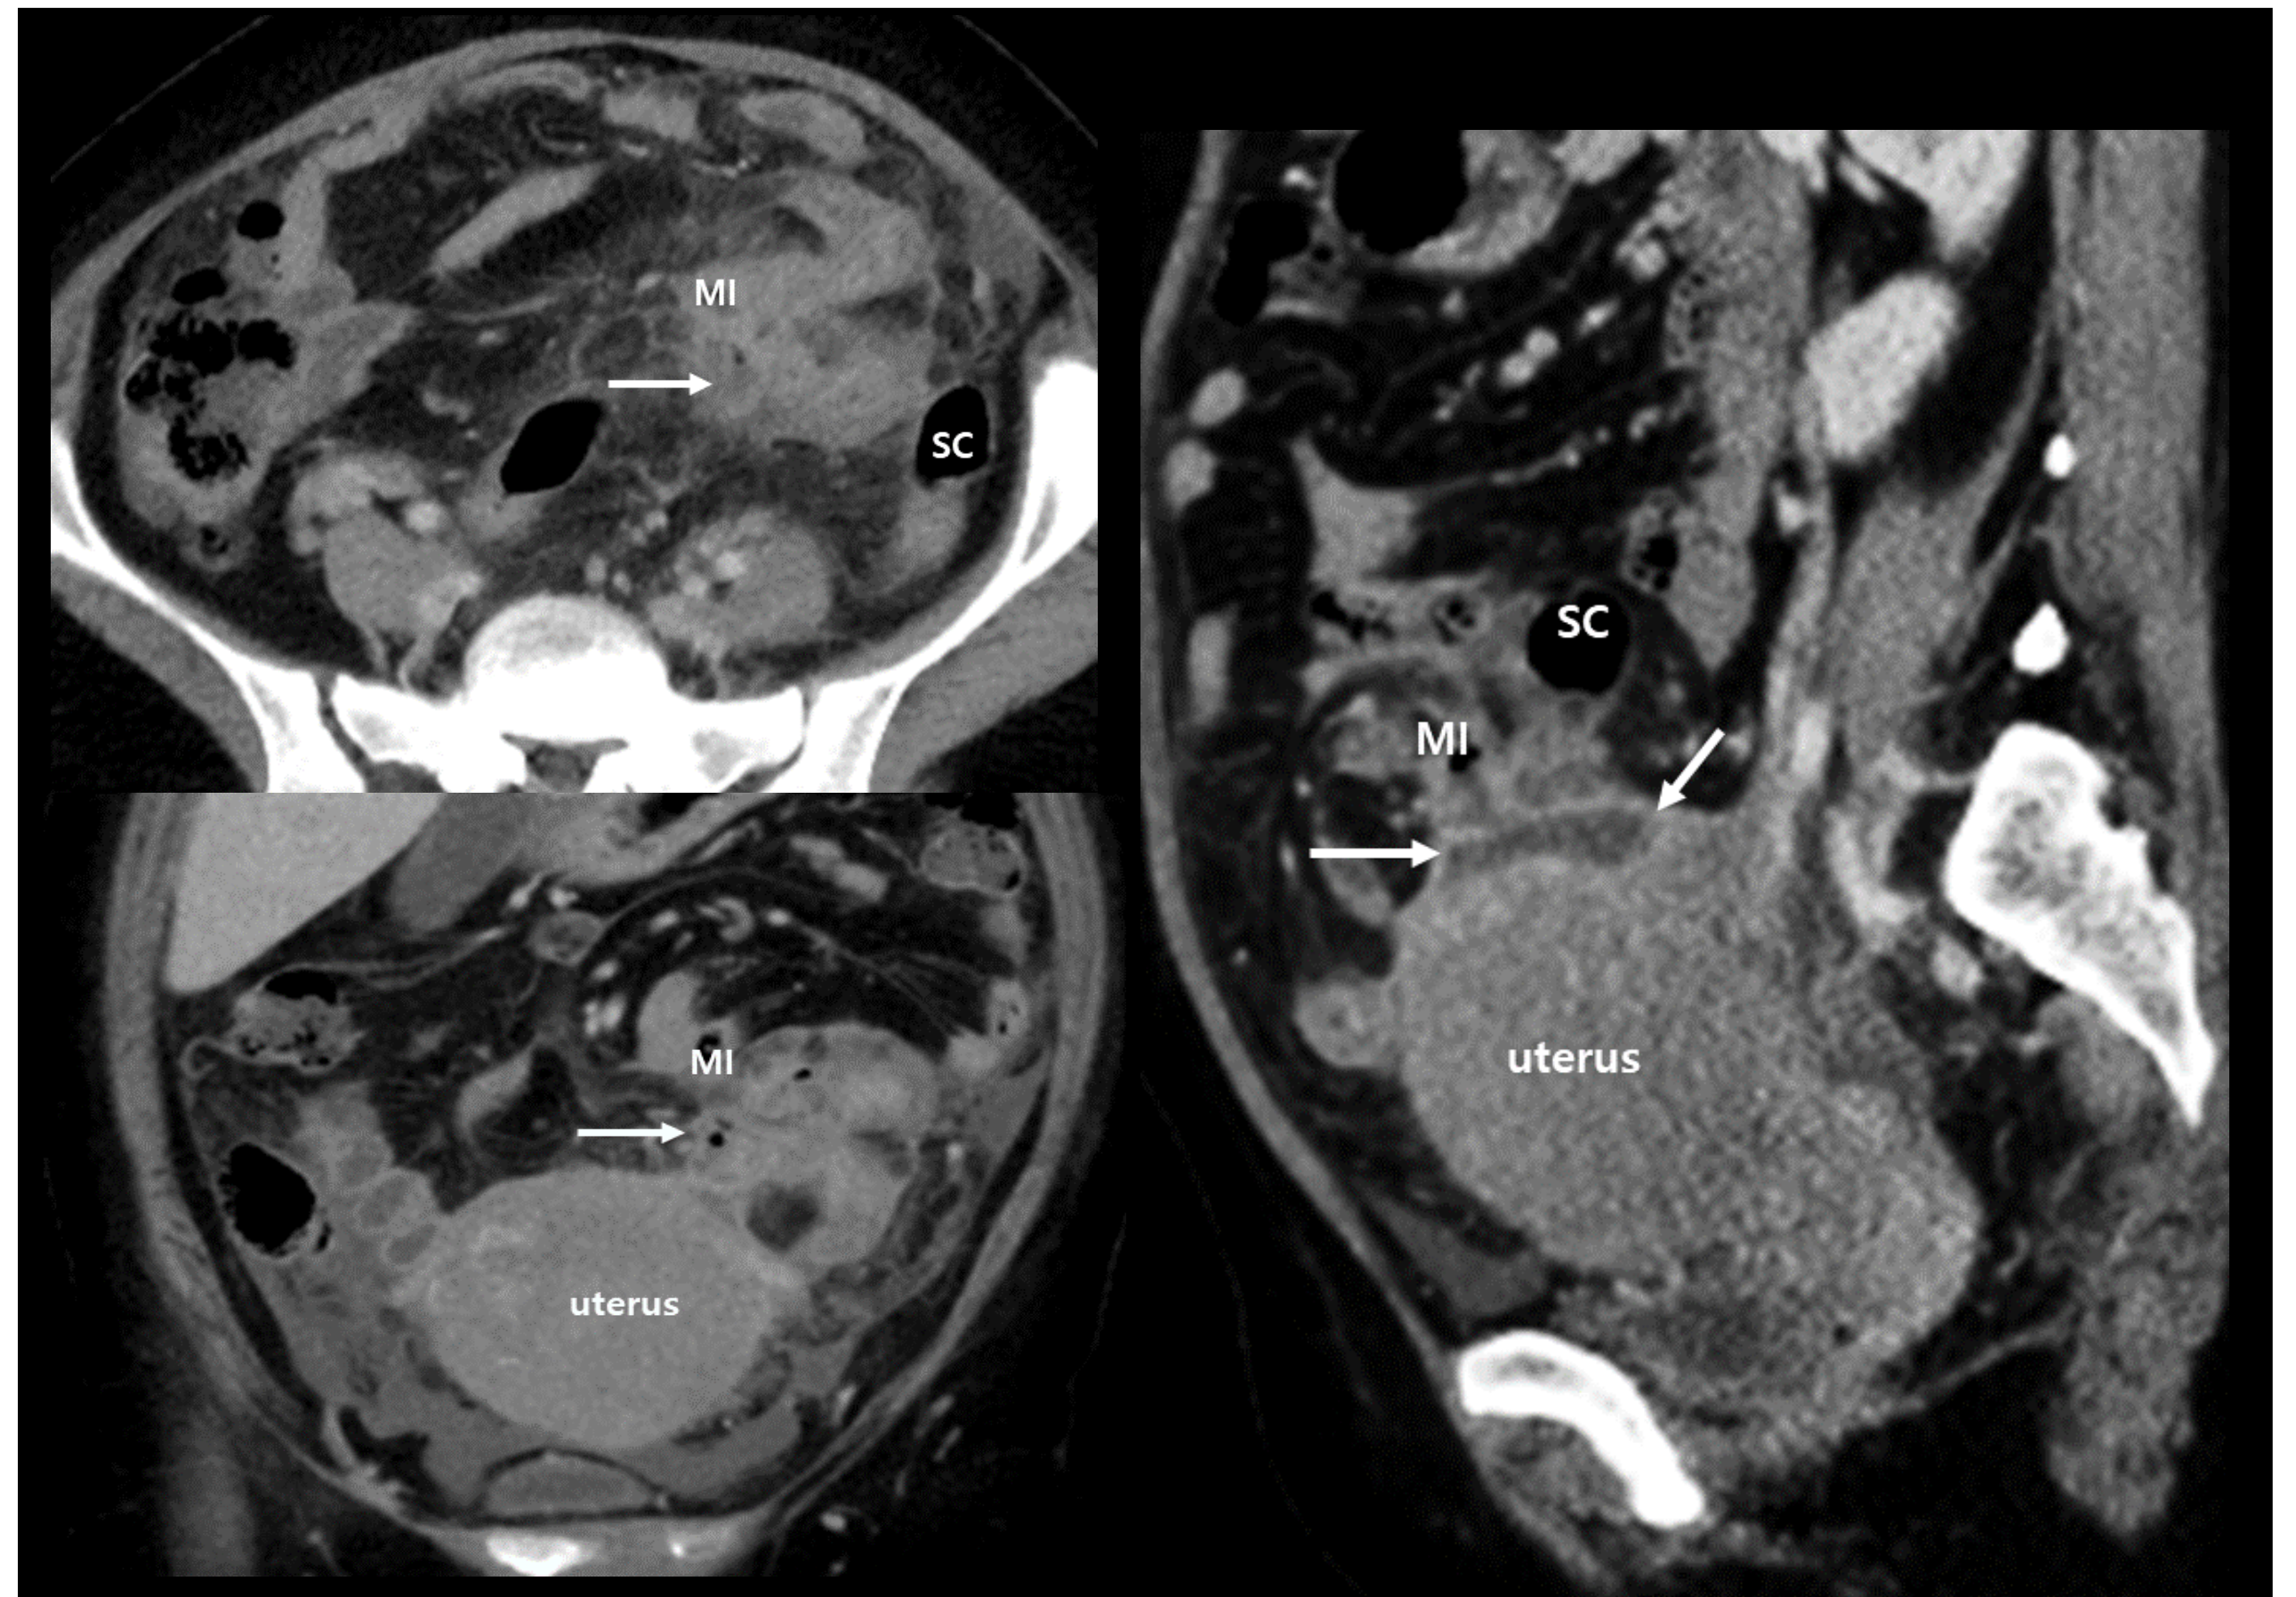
The computed tomogram of abdomen
